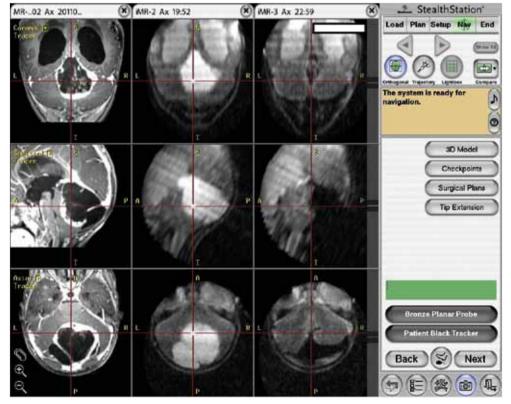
MR images in the navigation screen. The left column shows preoperative images and middle column shows the lesion at the beginning of the operation. The right column confirms the total resection.
